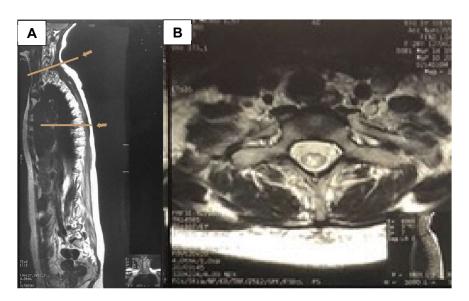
Whole Spine MRI 1,5 T during admission with T2 Sagittal (A) and T2 Axial (B) with transverse myelitis more than 3 segments of vertebrae and involvement of the central cord.
